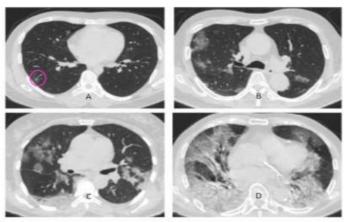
CT image of coronavirus disease-2019 by disease severity. A. An axial CT image in a 26-year-male mild type patient (3 days from symptom onset to CT scan) GGO in right lung. B. An axial CT image in a 69-year-male common type patient (7 days from symptom onset to CT scan) shows multiple GGO in both lungs. C. An axial CT image in a 55-year-female severe type patient reveals extensive GGO and pulmonary consolidation. D. An axial CT image in an 83-year-male critical type patient (7 days from symptom onset to CT scan) reveals wide ground-glass opacities in multiple lobes, relative formatting "white lung".
